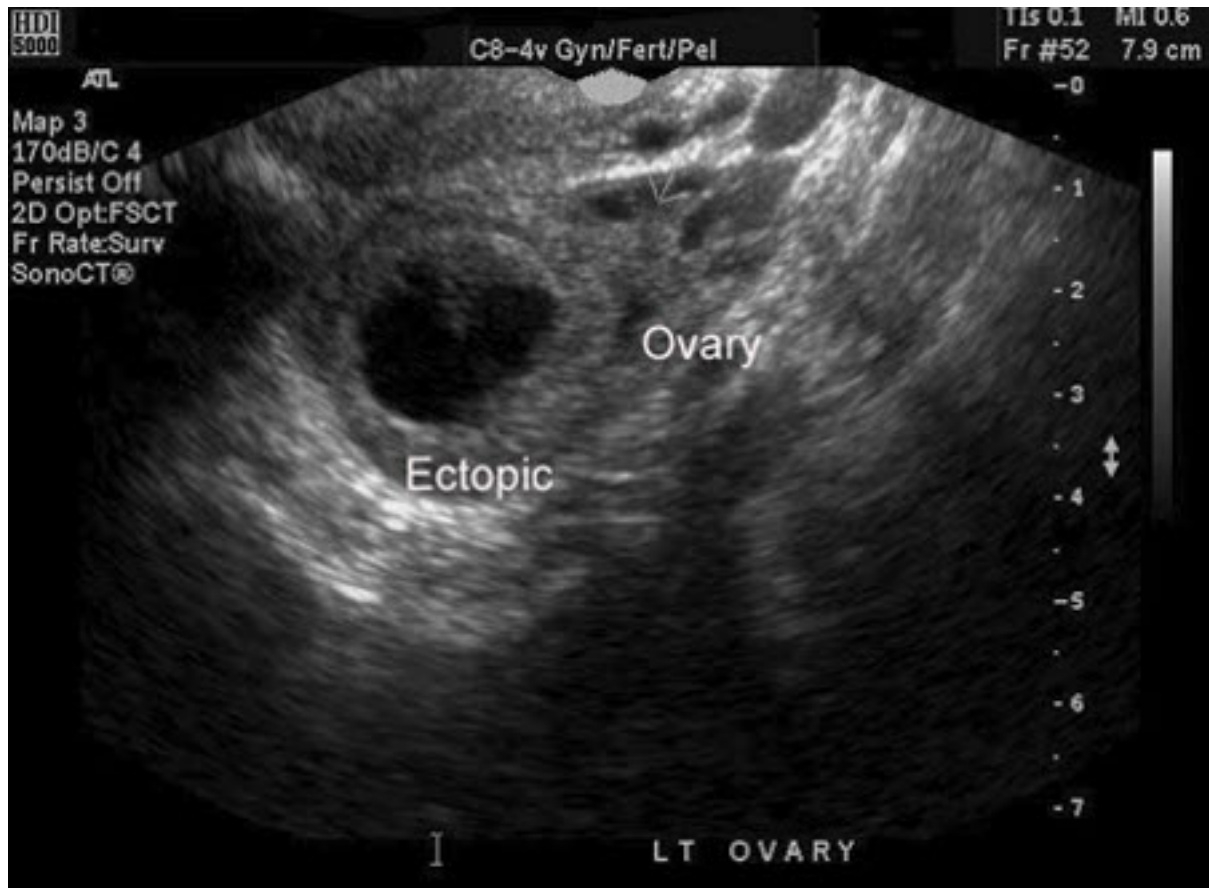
Ectopic pregnancy: Ultrasound image of ectopic pregnancy
